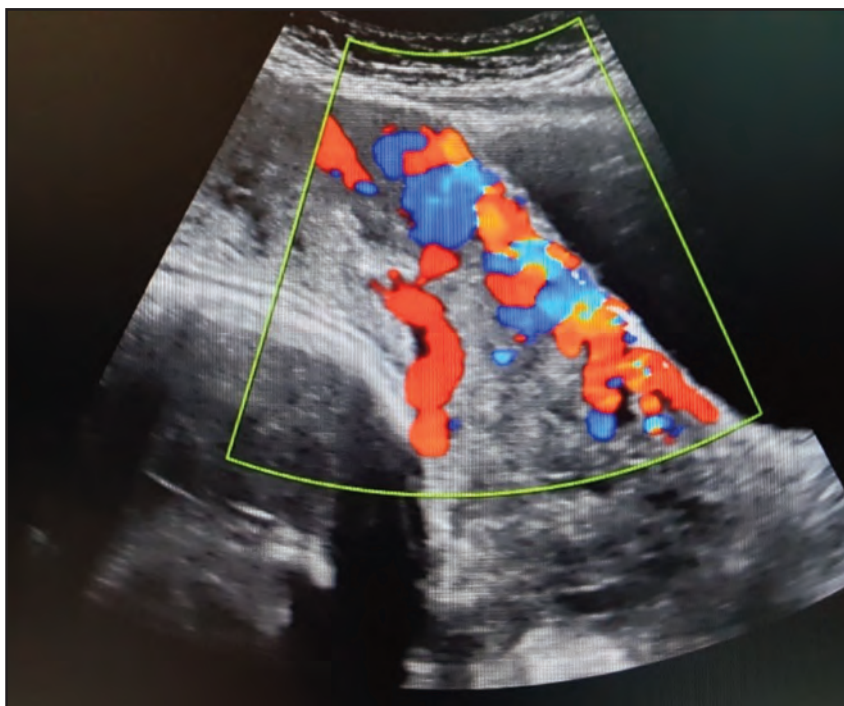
USG Color Doppler image showing hypervascularity at utero-vesical interface
